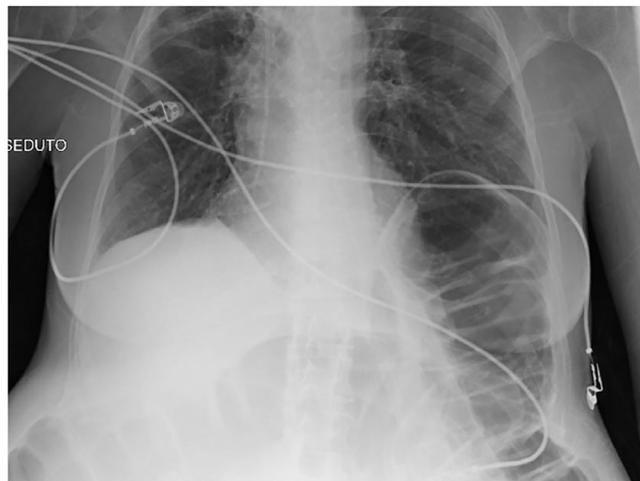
Radiograph of the chest and the upper abdomen, showing elevation of both hemidiaphragms and marked gaseous distension of large bowel loops.
